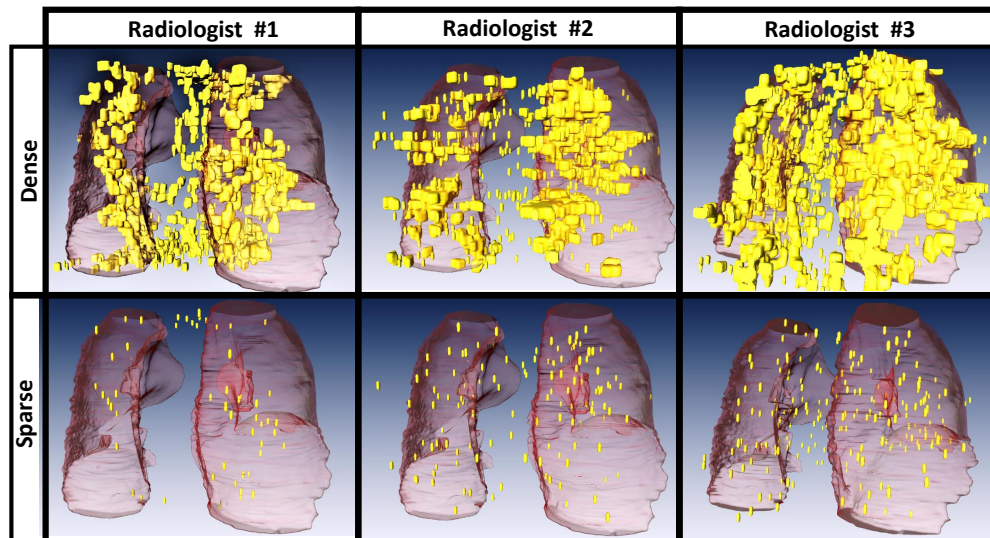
Lung cancer screening experiment with CT data. Dense and sparse gaze points on 3D lung surface.
